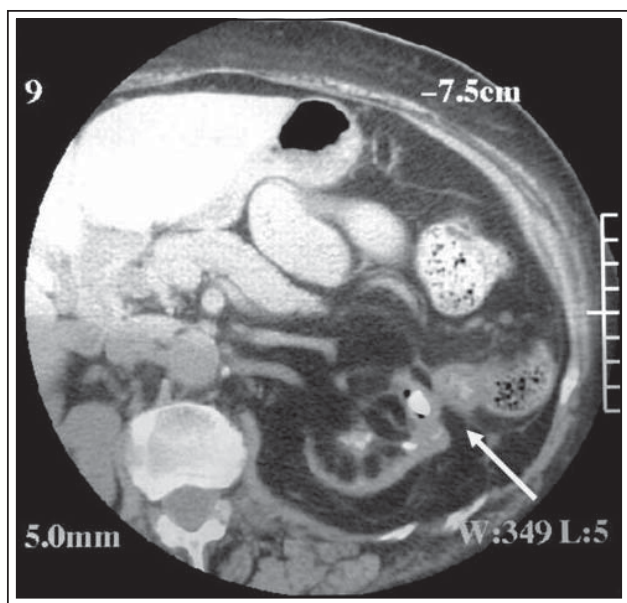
CT scan of abdomen and pelvis demonstrates air and staghorn calculus in left renal collecting system with cortical atrophy and inflammatory stranding in the left mesocolon. The upper to middle pole of the left kidney appears inseparable from a portion of the proximal mid-descending colon, with a presumed fistula between the colon and kidney accounting for the presence of renal air.
